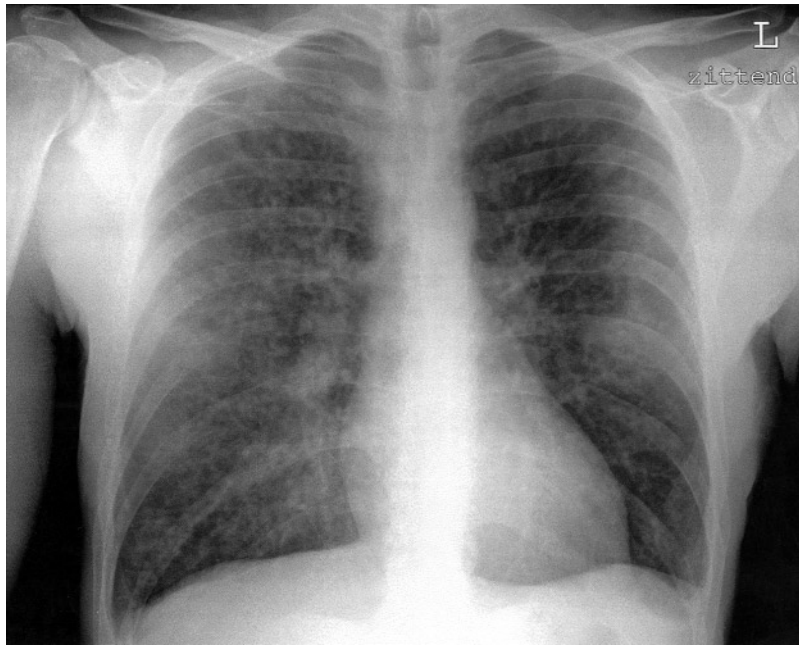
Radiograph of the thorax shows diffuse bilateral interstitial nodular infiltrates.
